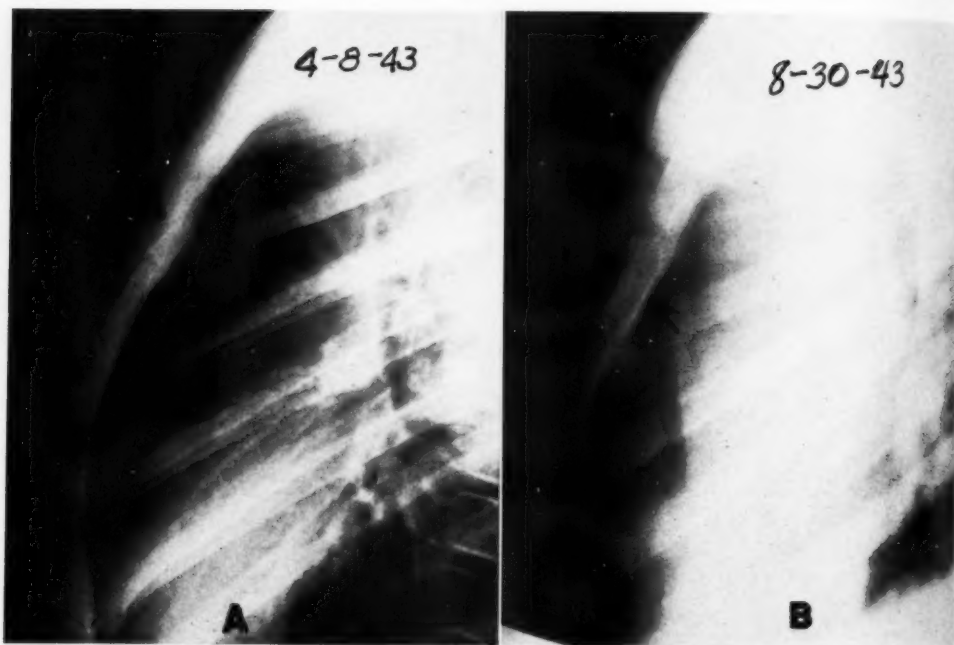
Case 4: A. Recent fracture of upper sternum, not previously recognized or suspected, revealed by x-ray study because of breast nodule. The patient, a 13-year-old boy, had fallen five weeks previously but had no recollection of striking any part of the chest wall.
